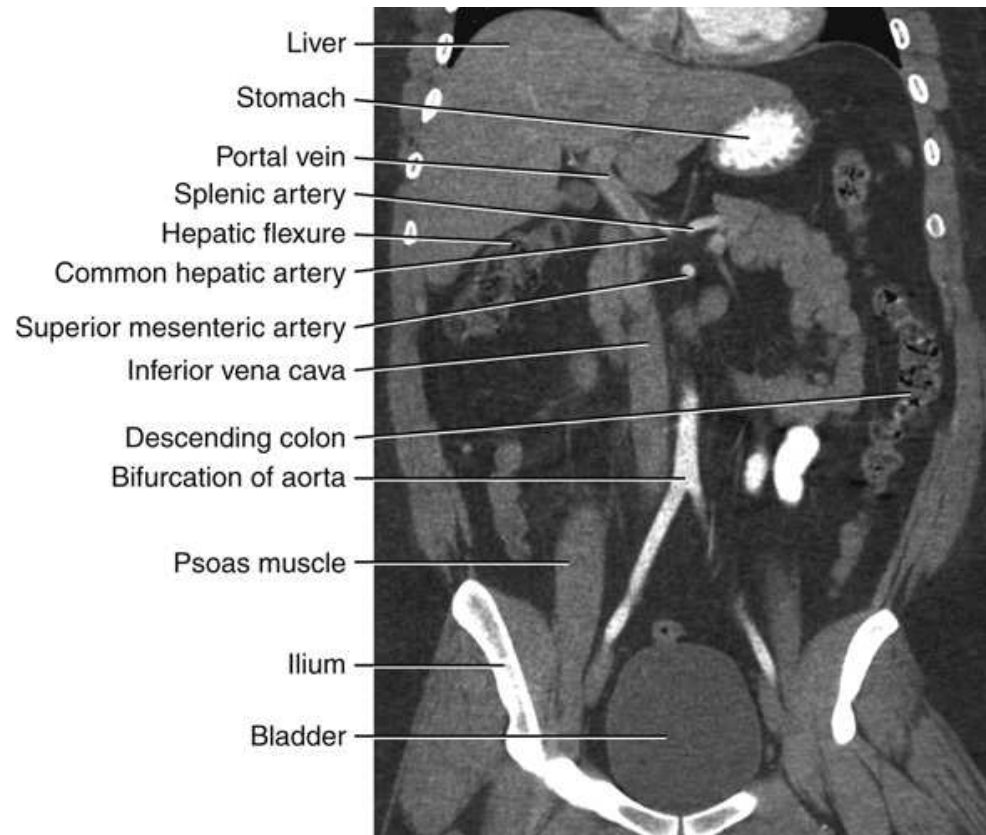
Coronal CT image through central abdomen.
